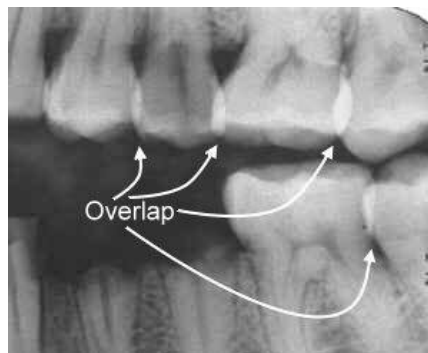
Example of overlap on a bitewing radiograph, obscuring any caries that may be present. Cases of overlap can occur either due to the anatomy of the examined mouth or to the misangulation of the X-ray beam, which should be perpendicular to the receptor.
